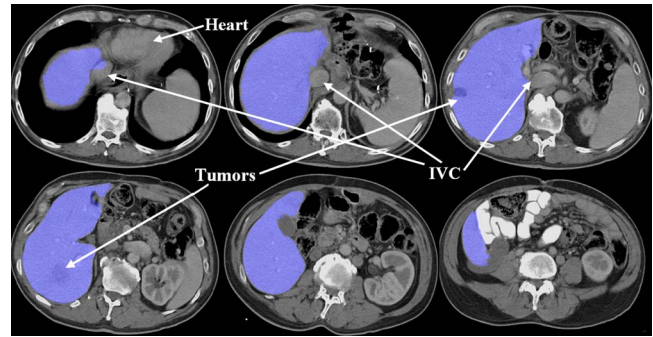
An example of pathological liver segmentation from the MICCAI data. 2D axial slices of the 3D CT data are shown.
